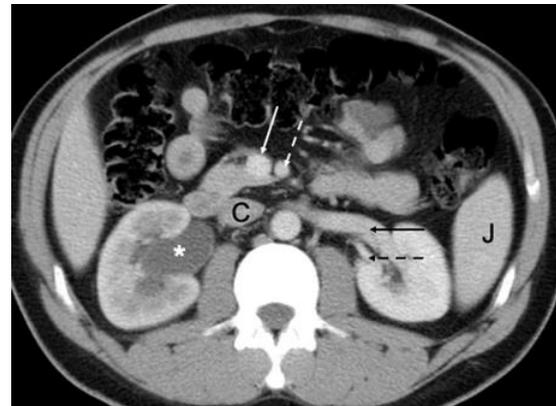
A contrast-enhanced CT scan of a 34-year-old male shows hydronephrosis (white asterisk) of the right kidney which was due to a ureteric calculus in the distal right ureter (not seen in the image). Hydronephrosis can occur due to obstruction of the ureter by intraluminal, intramural or extramural causes. Some of these include renal and ureteric calculi, ureteric strictures, malignancy or prostatic pathologies. The left renal vein (solid black arrow) is anterior to the abdominal aorta and joins the inferior vena cava (C). The left renal artery (dashed black arrow) is posterior to the renal vein and arises from the lateral aspect of the abdominal aorta. The spleen (J) is also visible in this image. Solid and dashed white arrows point to the SMV and SMA, respectively
